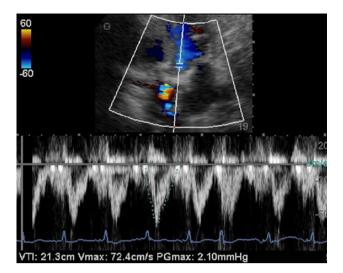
LVOT pulsed-wave Doppler apical 5-chamber view
